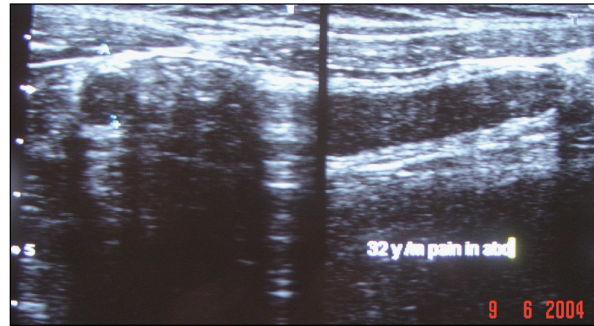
Transverse and longitudinal ultrasound images showing enlarged appendix (Distance between calipers = diameter of appendix = 9 mm).
